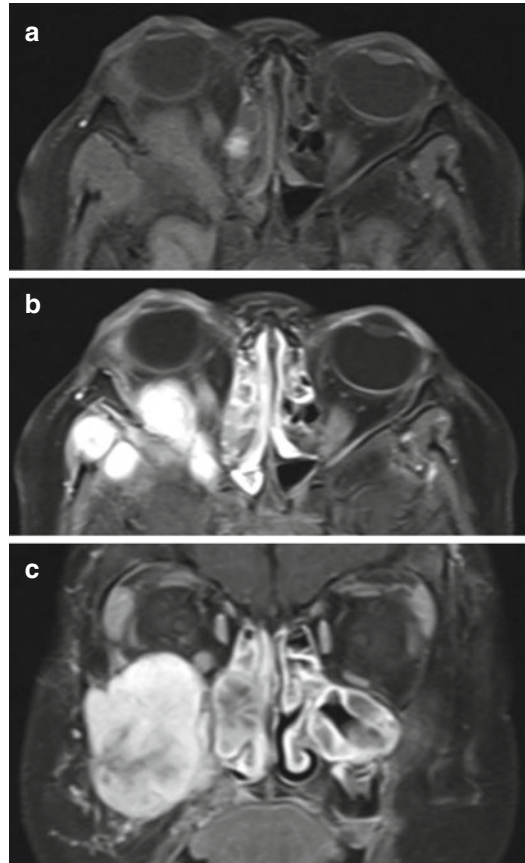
Osteosarcoma; a 5-year-old-female presented with facial asymmetry and a right maxillary lesion involving the inferior orbit. (a) Axial T1 pre-contrast MRI shows the mass involving the inferior orbit. (b) Axial T1 post-contrast MRI showing enhancement of the inferolateral intraconal lesion with extension into the temporal area. (c) Coronal T1 post-contrast MRI showing involvement of the inferior orbital wall and maxillary sinus. Biopsy was consistent with fibroblastic osteosarcoma. The patient subsequently underwent induction chemotherapy with debulking of the mass and proton beam radiotherapy
